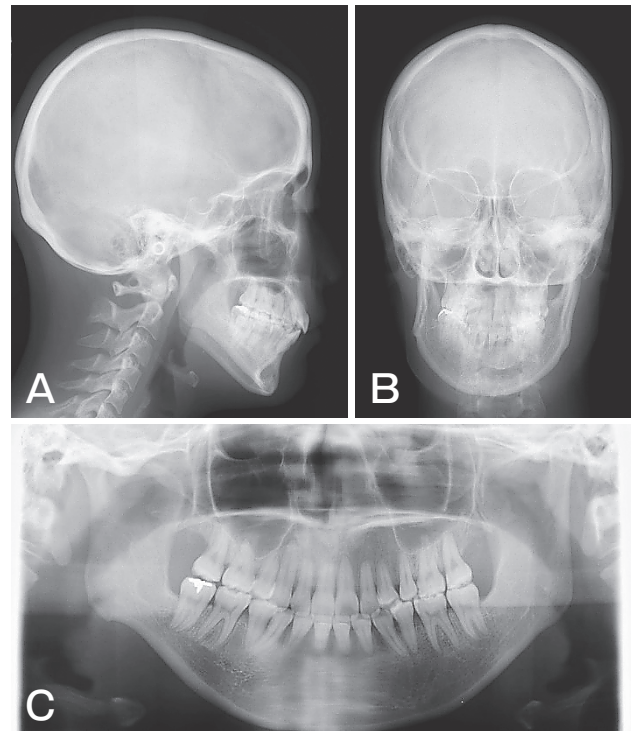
Posttreatment cephalograms and a panoramic radiograph. (A) Lateral cephalogram, (B) posteroanterior cephalogram, (C) panoramic radiograph.
